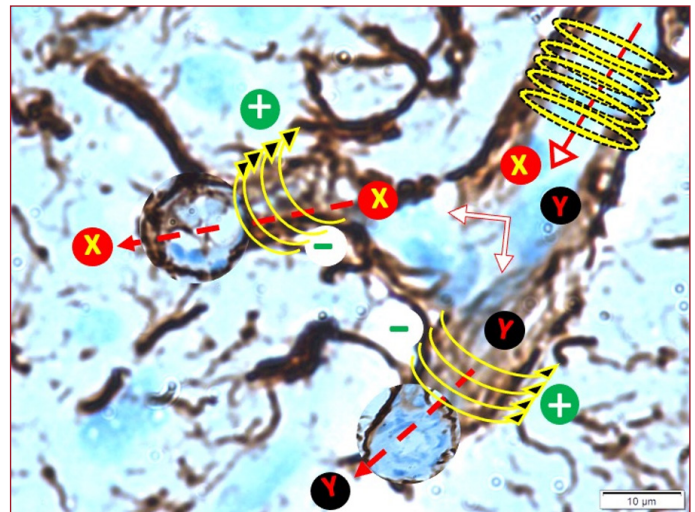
The blood brain barrier is found in sensitive areas of the brain. It consists of a multi-functional endothelium, a dense innervated smooth muscle layer, and a neurovascular structure surrounded by a dense network of astrocytes surrounding the adventitia. Glial cells determine and direct the flow direction of the particles flowing in the vessel by producing negative and positive currents just like the X-Ray device. In the figure, while XY particles flow distally, positive, and negative charges direct the X and Y particles to separate channels. Some of the astrocytes surrounding the artery may be acting as anode, and the opposite astrocyte cluster may also act as a cathode. This mechanism, which is viewed individually in two dimensions in the cross-section, exhibits a spiral structure. This neuroelectromagnetic mechanism may direct the particles in the vasculature to the neural, humoral, endocrine, and immune components of the brain according to their load and electromagnetic properties.
